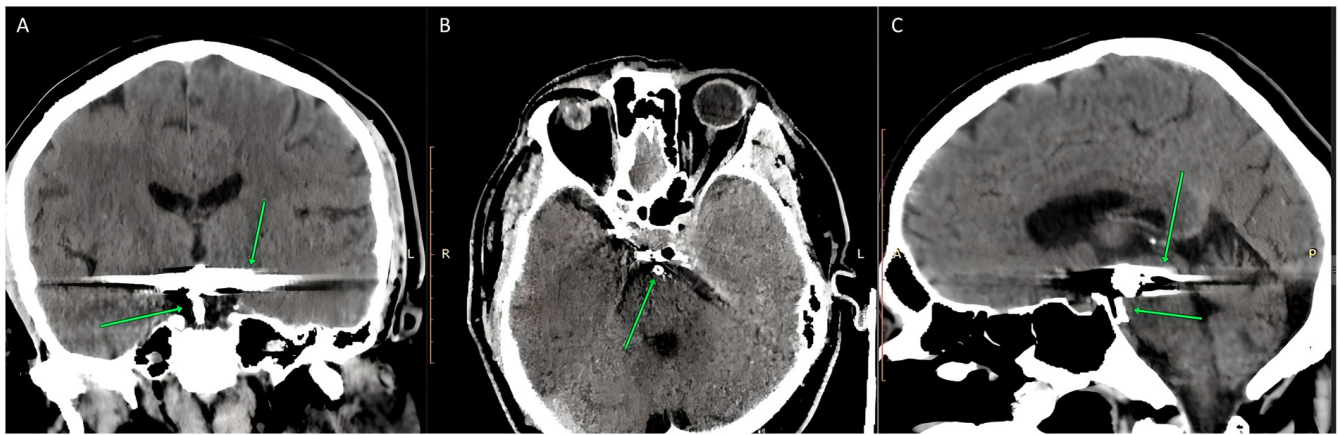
Computed tomography scans of the brain. (A) A posterior view of the stent, the arrow in the lower side of the picture shows the stent and the arrow from the upper side of this image shows the metallic artifacts from pieces that were used for the surgical repair of the cerebral artery aneurysm of the anterior communicating artery. (B) An axial view of the stent that was used to repair the basilar artery tip aneurysm, the arrow points to the stent. (C) A sagittal view of the stent that was used to repair the basilar artery tip aneurysm and it is indicated by the arrow from the lower part of the image. In addition, a sagittal view of the metallic artifacts from pieces that were used for the surgical repair of the cerebral artery aneurysm of the anterior communicating artery, which are indicated by the arrow from the upper part of this image.
